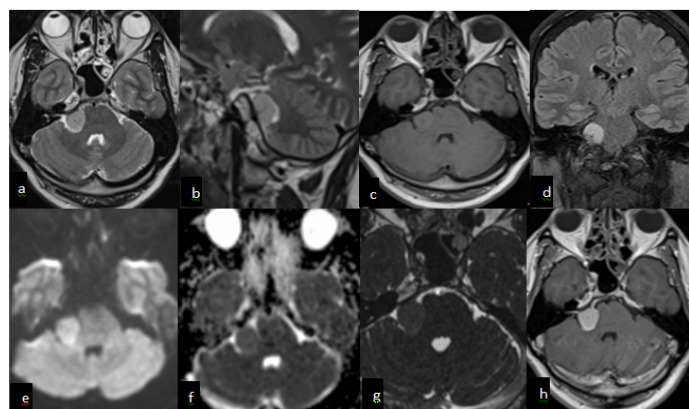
Right cerebellopontine angle meningioma presenting with chronic headache, tinnitus and dizziness. (a,b) Axial and sagittal T2-weighted image demonstrates small round dural based solid mass lesion in right cerebellopontine angle region (c) the lesion appears iso on T1-weighted imaging and (d) hyperintense on FLAIR images. (e,f) The lesion show homogenous diffusion restriction. (g) Constructive interference in steady state axial image shows well defined right CPA mass lesion (f) Axial post-contrast T1-weighted image shows vivid and homogeneous contrast enhancement of the mass. The lesion shows mass effect over pons and cerebellar peduncle
